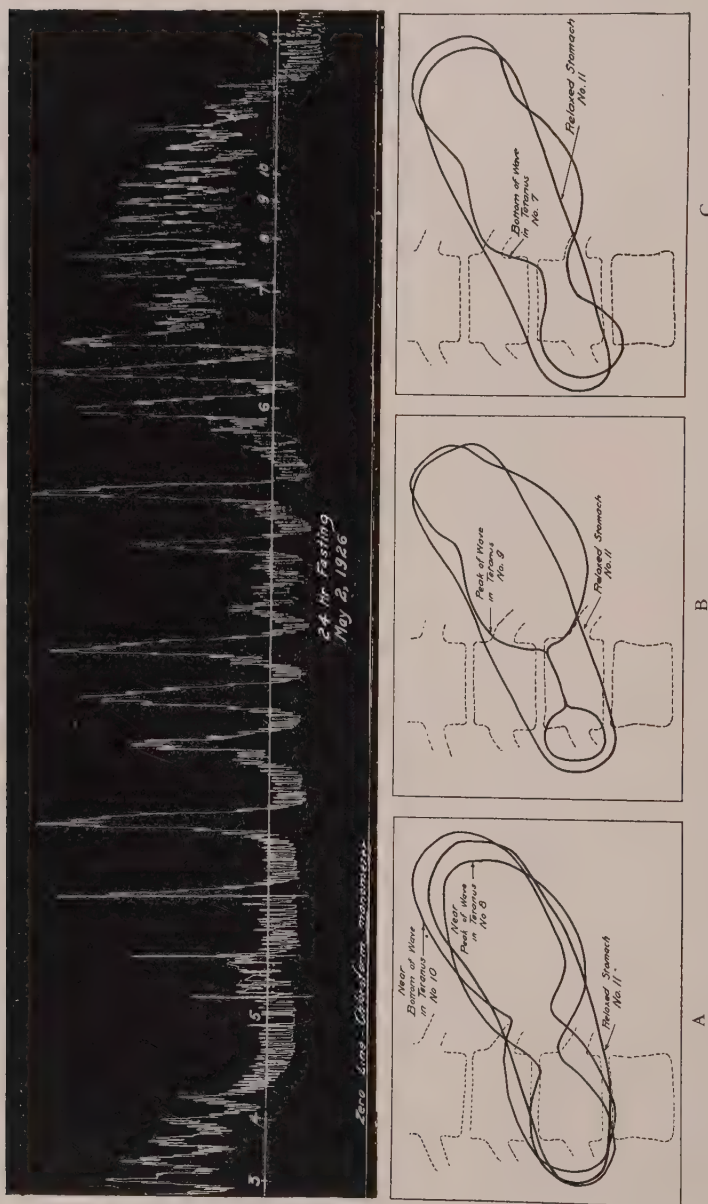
Kymographic tracing of hunger contractions together with tracings (from roentgenograms) showing the shape of the stomach (A) during partial tetanus, (B) during the peak of a contraction wave superimposed on partial tetanus, and (C) at the bottom of a contraction wave during partial tetanus. (From Martin and Rogers.)
